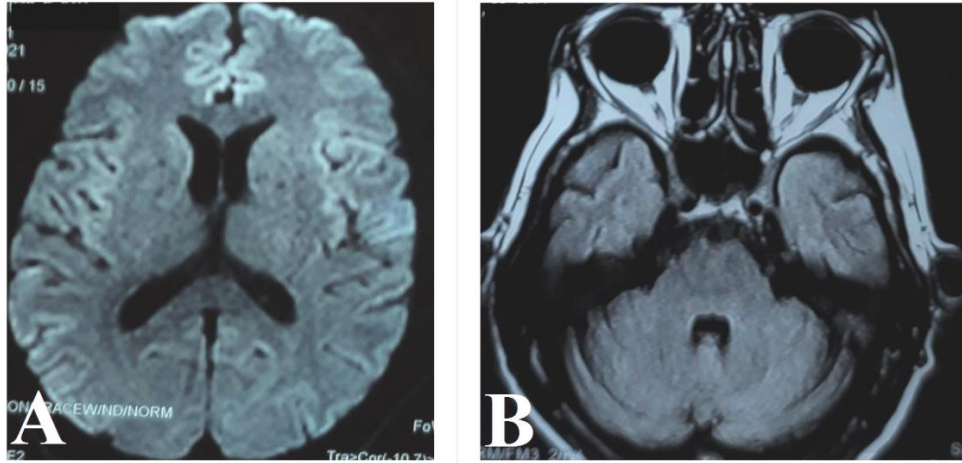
MRI brain showing axial diffusion weighted image (DWI) of brain with no restriction in splenium of corpus callosum (Panel A); axial T2 FLAIR sequence showing resolution of hyperintensities in dentate nucleus of cerebellum (Panel B)
